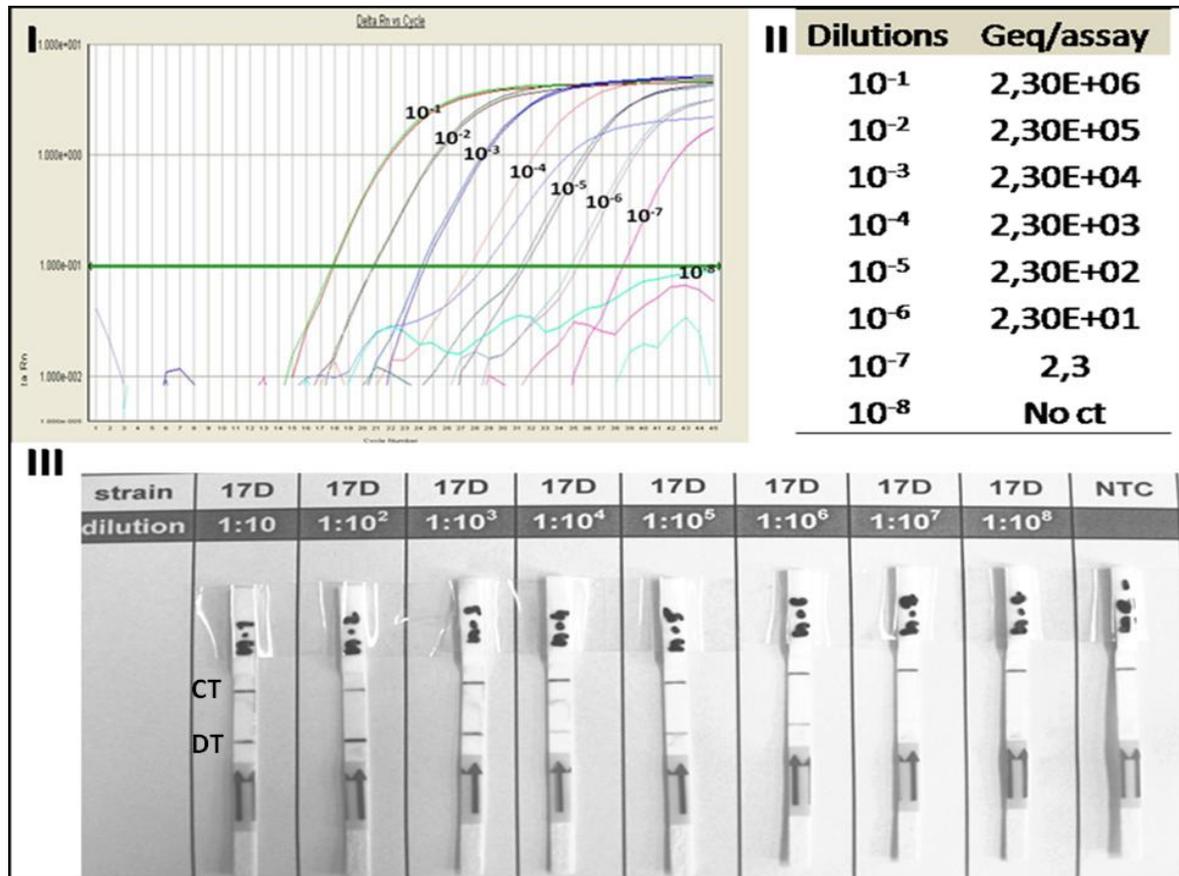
Figure C-3. Sensitivity of LFS-RPA assay vs. sensitivity of real-time RT-qPCR. I) The amplification plot of the real-time RT-qPCR. II) The genome copies/rxn determined in 10-fold serial dilutions by the real-time RT-qPCR. III) The sensitivity of LFS-RPA assay by detection on the LFS as an endpoint analysis. CT: control line, DT: detection line.
